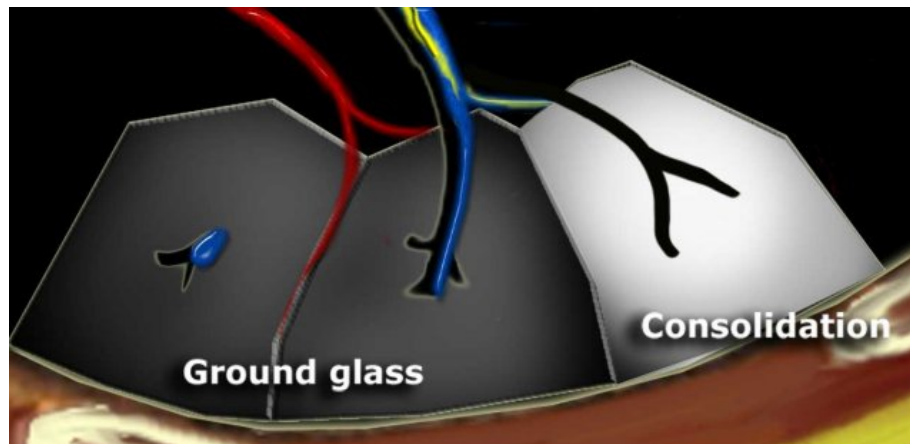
Comparison of ground-glass opacity versus consolidation on CT
